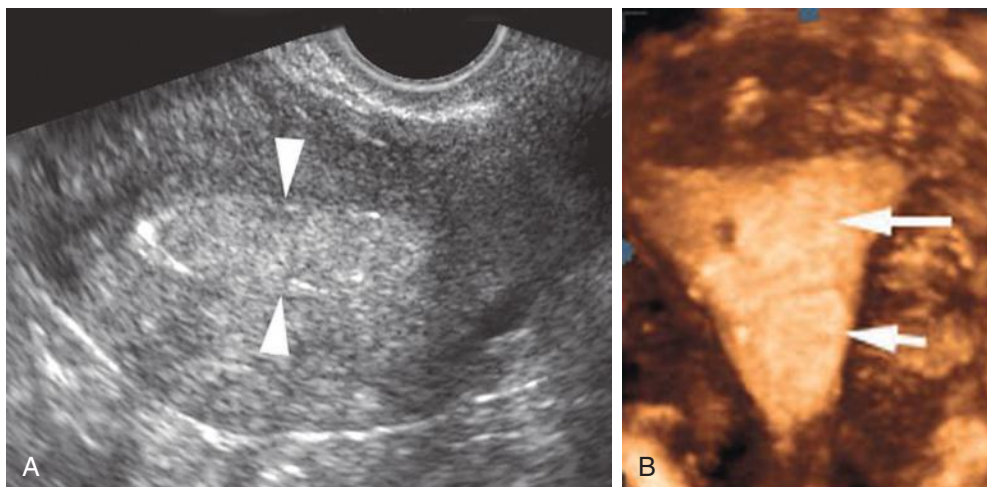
A 62-year-old woman with postmenopausal bleeding. A, Transvaginal sonography shows homogeneous echogenic thickening of the endometrial echo complex (arrowheads). B, Coronal three-dimensional image shows two subtle hyperechoic intracavitary masses (arrows). The additional information allowed triage to hysteroscopically guided biopsy and removal, confirming endometrial polyps.
